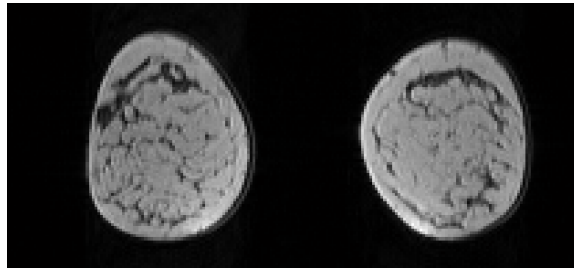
A precontrast DCE-MRI slice
